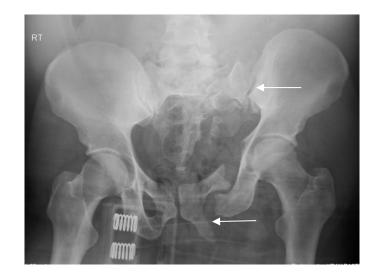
Mounted Casualties: Case Study 1: radiograph demonstrating a left superior and inferior rami fracture, and a left scral fracture extending into the left SIJ. Pelvic binder is in situ.
